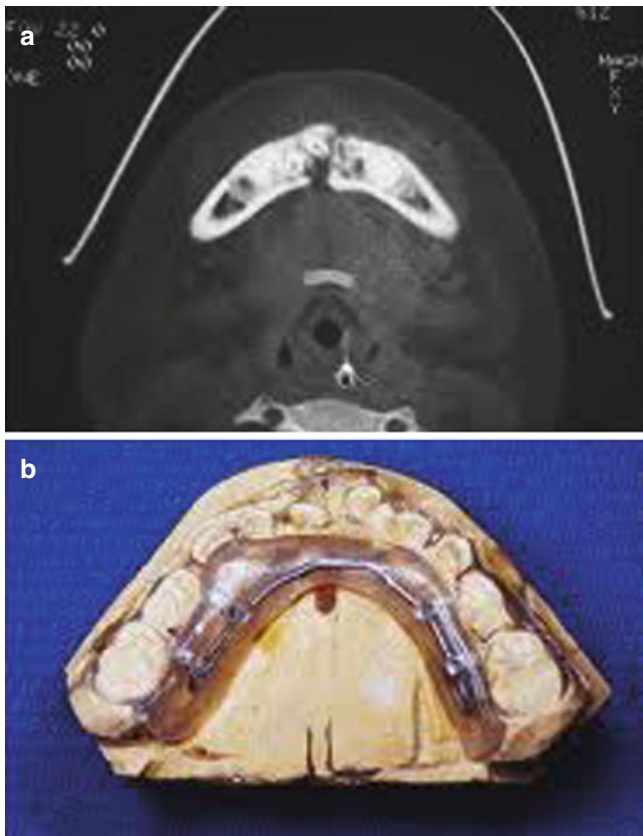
CT scan of a displaced symphyseal fracture involving the alveolar ridge (a). Lingual splint used to hold the alveolar segments together (b)
